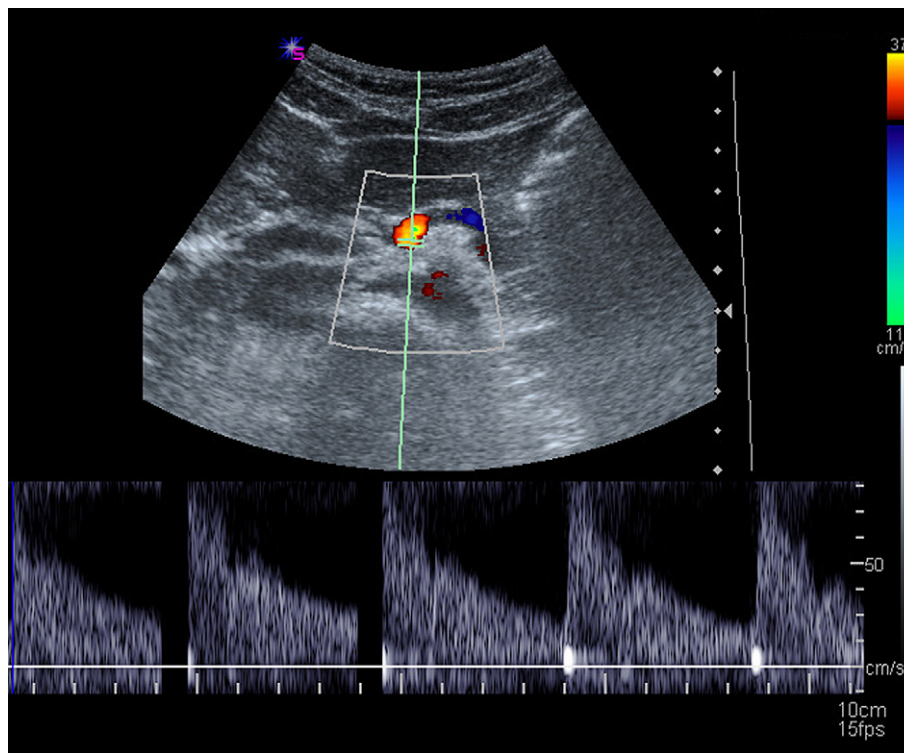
The Doppler tracing of the celiac trunk is characterized by large diastolic component.
